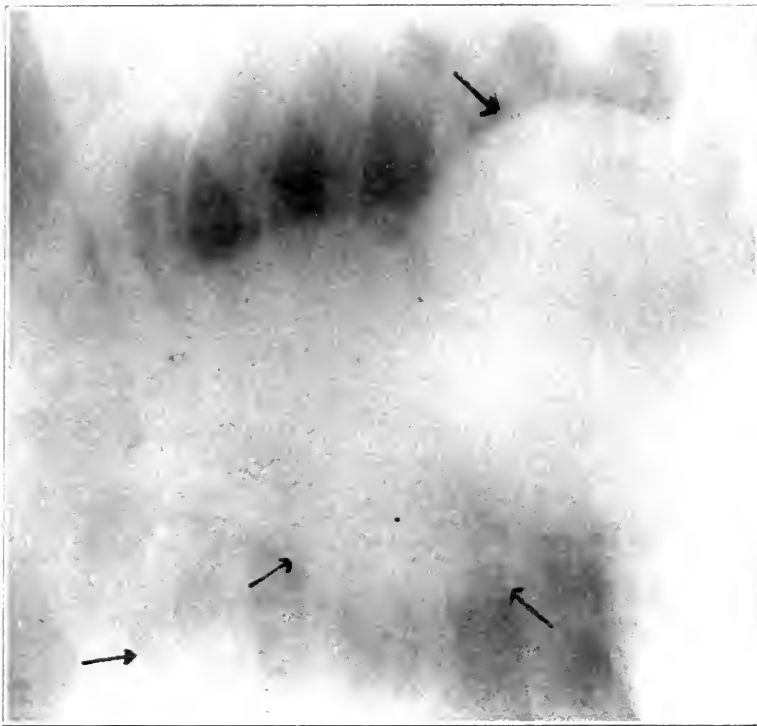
Roentgenogram of patient suffering from aneurysm of ascending portion of aortic arch. Note the transverse position of the heart with round left ventricle. Note also condition of right upper lobe of lung, probably a syphilitic induration of the lung.
